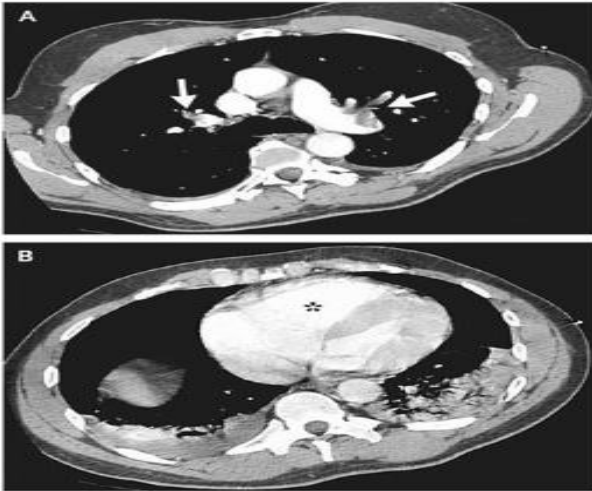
Chest computed tomography angiogram showing pulmonary embolism.
